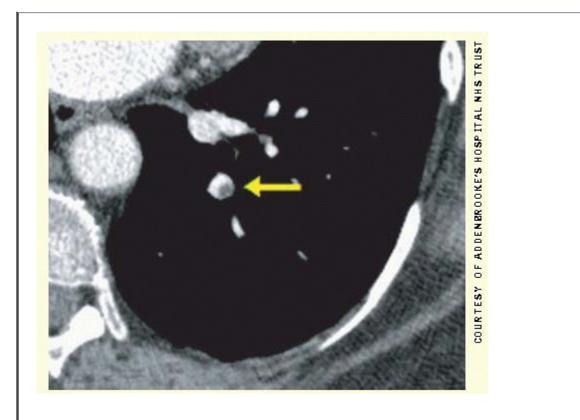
CT pulmonary angiogram (CTPA) showing a filling defect consistent with an embolus within a branch of a left pulmonary artery.
